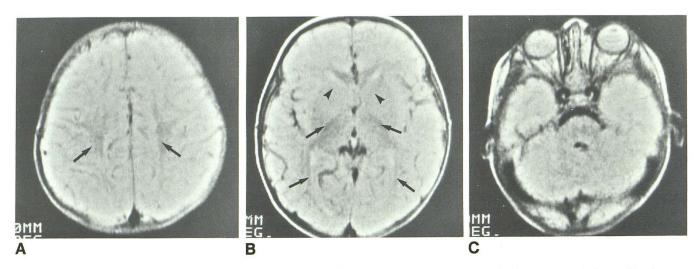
Isointense pattern in 10-month-old girl. Axial MR images (SE 2000/84). Signal intensities of gray and white matter are similar at all levels. A, Myelination present in white matter of centrum semiovale (arrows).
